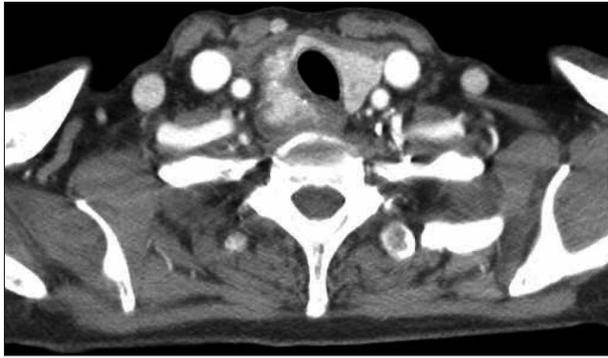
Neck computed tomography section before thyroidectomy (pre-op evaluation).
